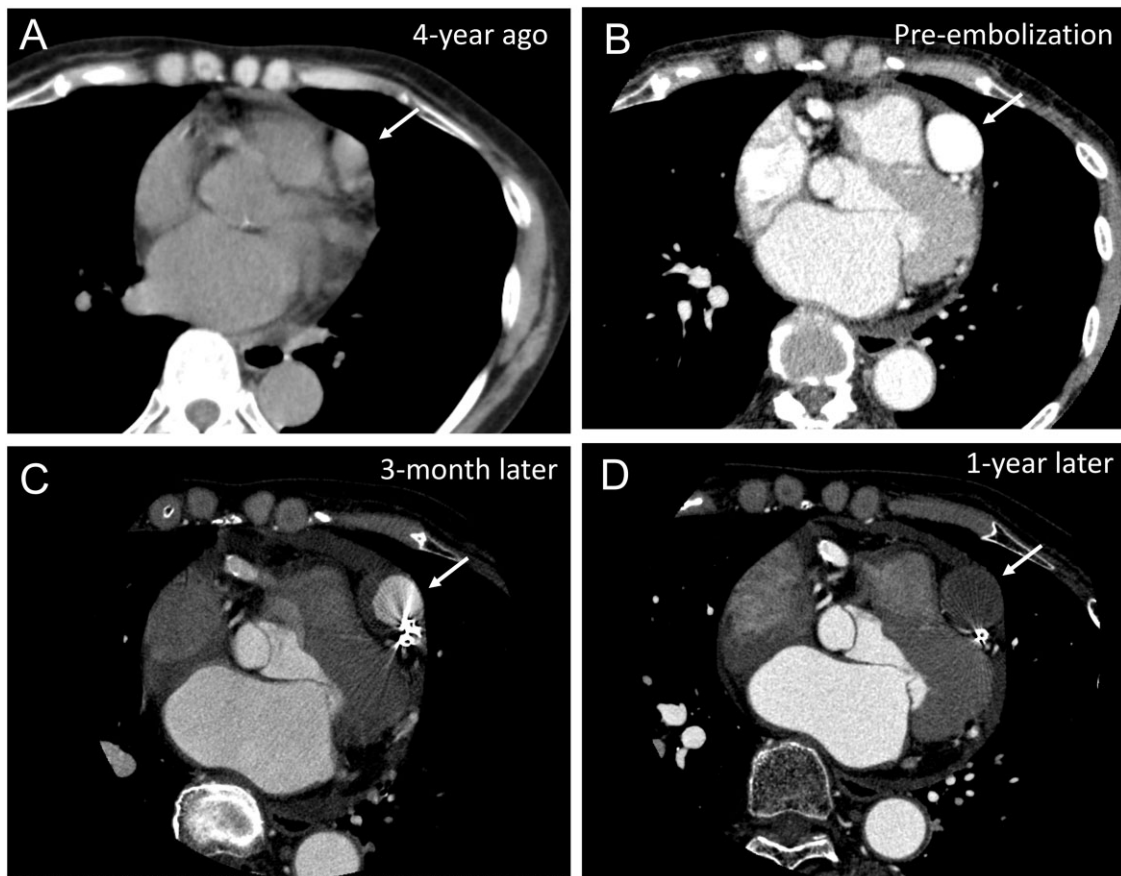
Serial cardiac computed tomography. Serial cardiac computed tomography findings (A) 4 years ago, (B) pre-embolization, (C) 3 months later, and (D) 1 year later. White arrows showed sacular aneurysm originating from the mid-left anterior descending artery.
